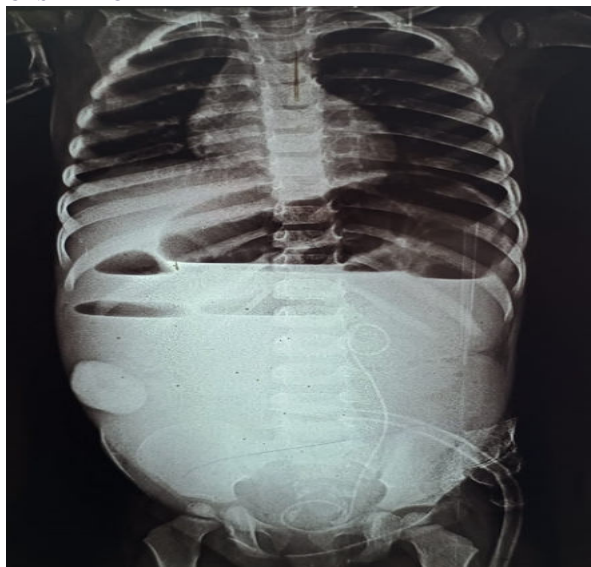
X-ray findings suggestive of intestinal obstruction.
